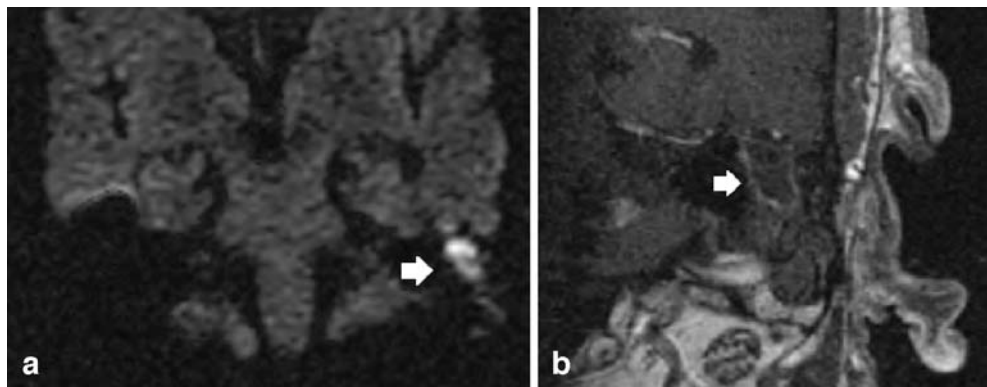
a A 60-year-old male suspected of having a primary acquired middle ear cholesteatoma. Coronal echo-planar DWI shows a clear hyperintense lesion in the left mastoid region under the tegmen (arrow). b Same patient as in a. Corresponding coronal T1-weighted image after gadolinium administration shows a non-enhancing
